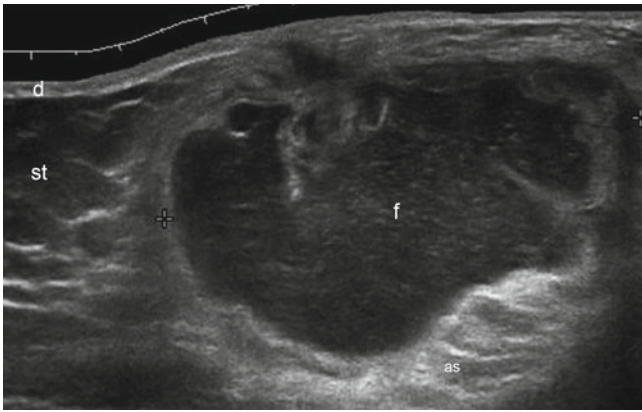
Fluid collection after abdominoplasty. Grey scale ultrasound image (transverse view, anterior wall) demonstrates an oval-shaped anechoic fluid collection that presents echoes (debris) and posterior acoustic reinforcement (ar). *Abbreviations:* d dermis, st subcutaneous tissue
